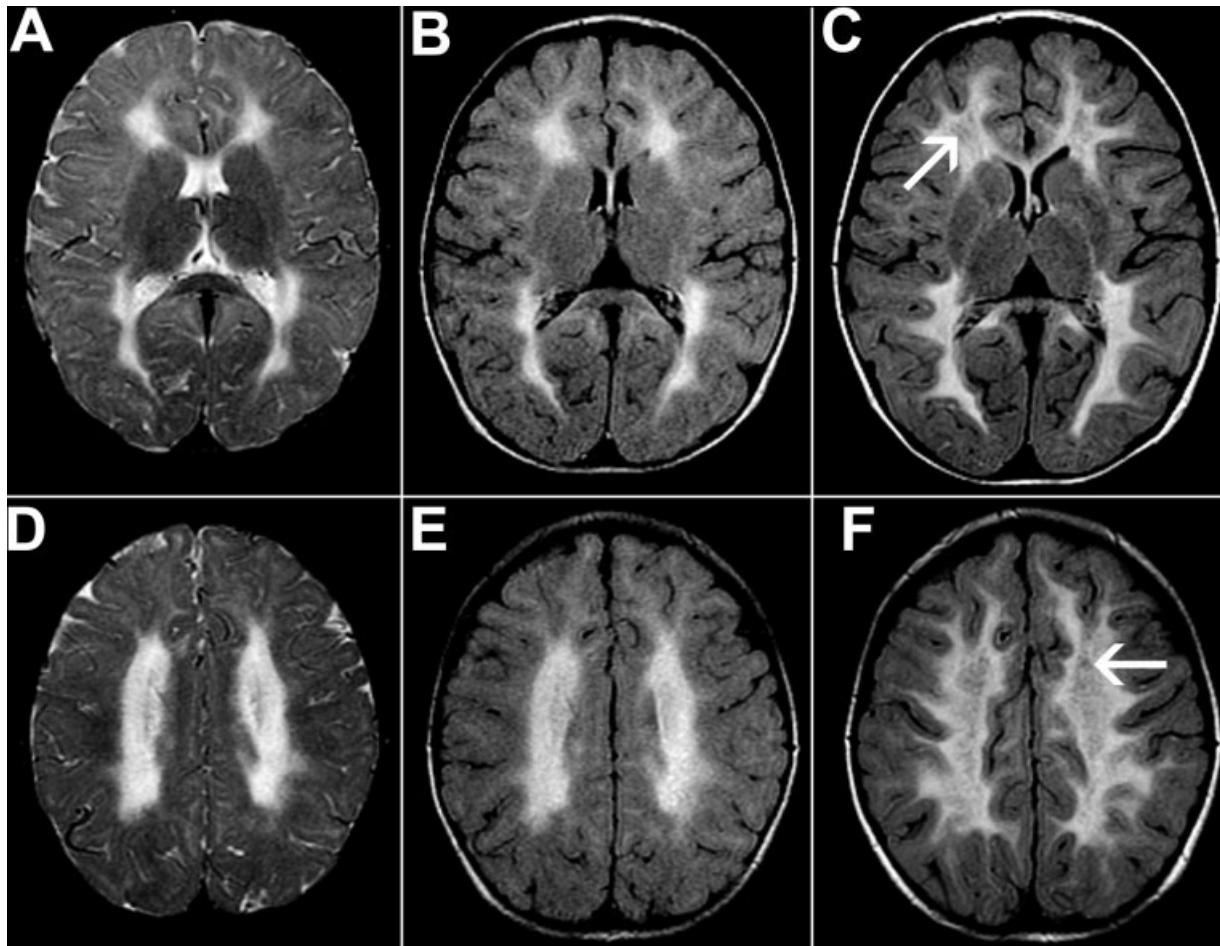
Early MRI with delayed myelination. T₂-weighted images (A, D) in patient 3 at age 1.7 years show abnormal periventricular and bordering deep white matter, while the subcortical white matter is not myelinated, indicative of significantly delayed myelination. On FLAIR (B, E), abnormal but non-rarefied white matter is hyperintense. At age 3.2 years (C, F), both FLAIR images show extensive cerebral white matter abnormalities and with rarefaction of the white matter (arrows).
